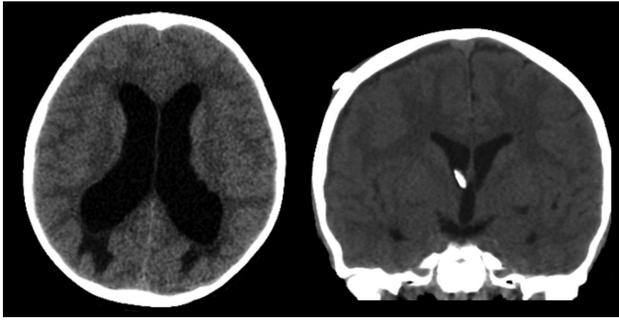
Left: Head computed tomography (CT) scan showing moderate communicating hydrocephalus. Right: Postoperative CT scan with resolution of hydrocephalus.
